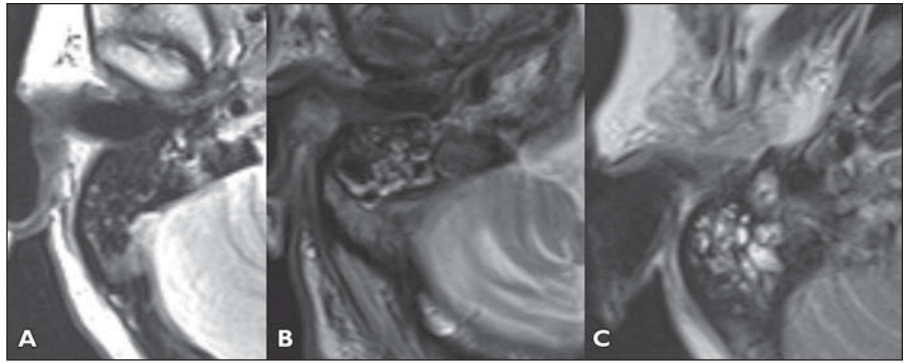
MR images show grading system for dural venous sinus thrombosis. A, Grade 1: curvilinear T2 hyperintensity is seen with mucosal congestion. B, Grade 2: thickened crescentic T2 hyperintensity is due to film or fluid overlying mucosa. C, Grade 3: complete T2 hyperintensity reflects fluid opacifying mastoid air cells.
